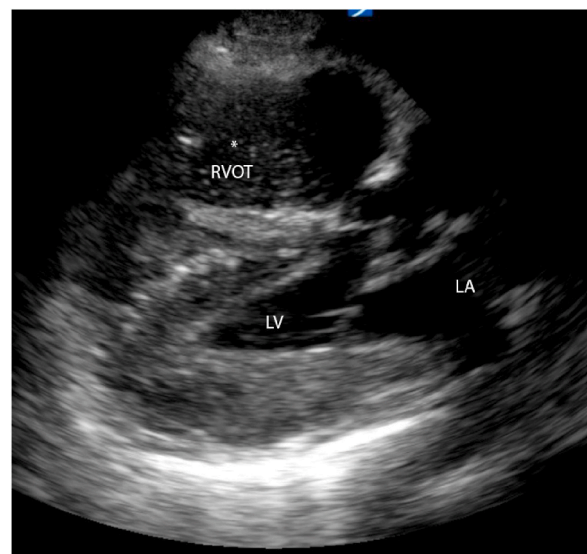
Parasternal long view of the heart on point of care ultrasound during hemodialysis pause just before cardiac arrest. Severely dilated RVOT with visualization of air bubbles. RVOT, right ventricular outflow tract; LA, left atrium; LV, left ventricle; *, air bubbles.
